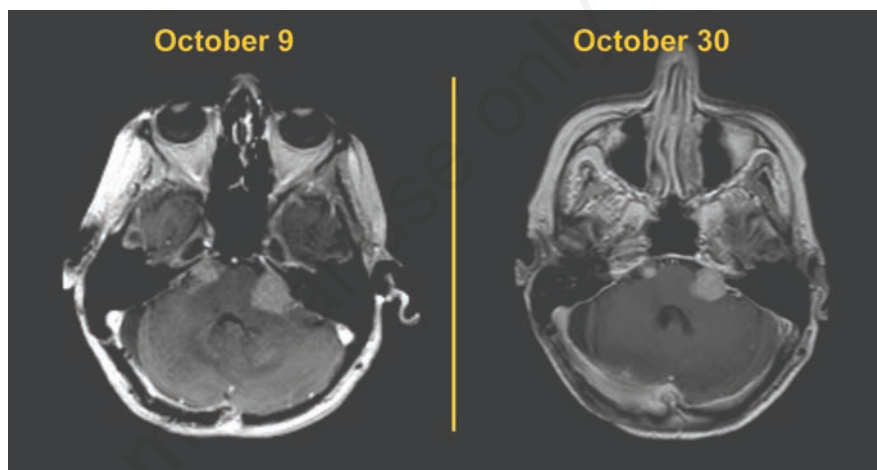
Post contrast T1-weighted axial images of the brain showing bilateral cerebellopontine angle drop metastases. The difference in technique accounts for the different image levels.
